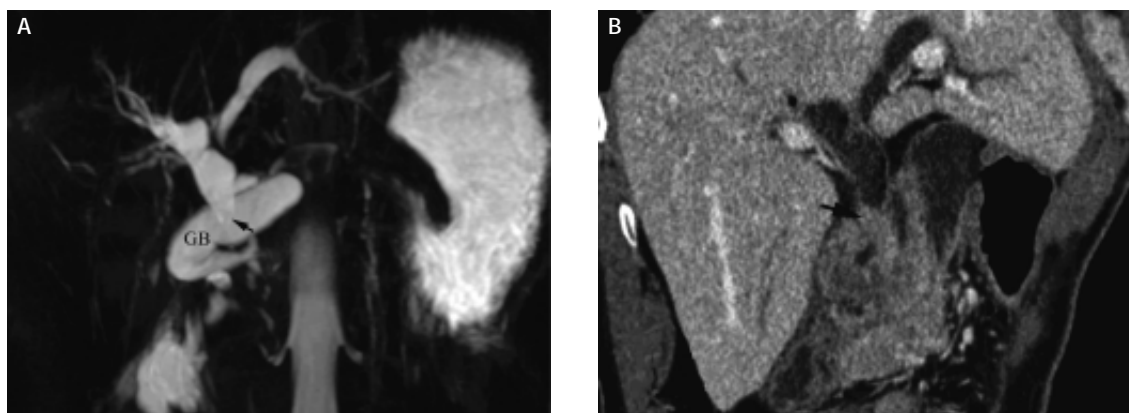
No. 5 patient, M/38, who had undergone an internal drainage with cystoduodenostomy 37 years ago, presented to our institution with vomiting after meal. A. MRCP showed extrahepatic bile duct disrupted (arrow). B. CT manifested a mass (arrow) deriving from bilioenteric anastomotic stoma. An exploratory surgery and biopsy revealed low-differentiated adenocarcinoma of distal bile duct.
